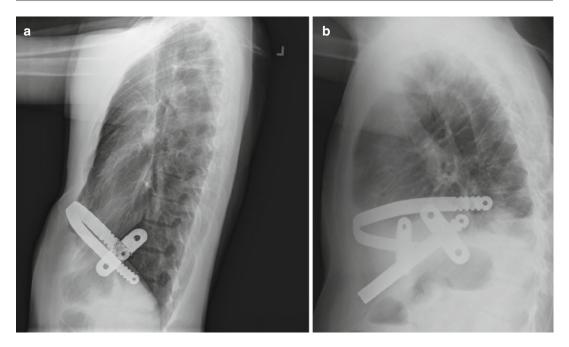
(a, b) Failure of the Nuss procedure can be due to bar rotation or migration as is seen in these two patient's lateral chest roentgenogram (a) rotation of a
